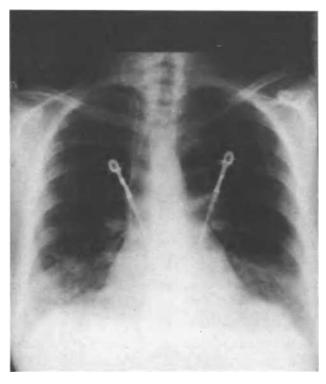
Posteroanterior chest radiograph taken (in the morning) 10 days after single left lung transplantation
